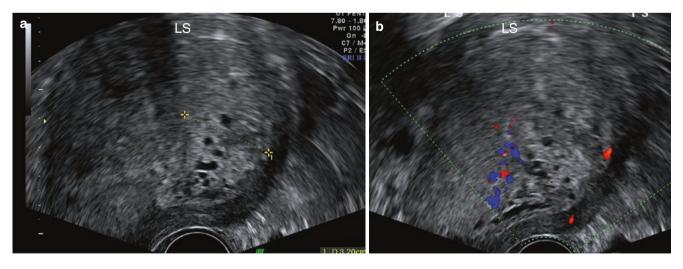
Molar pregnancy (complete mole) at 8 weeks and 3 days. (a) The endometrium appeared thick (3.2 cm) and heterogeneous and showed tiny cystic spaces within, leading to the suspicion of a molar pregnancy. (b) No significant flow is seen on colour Doppler within this tissue, which may be because of the uterine position and low velocity of flows. Beta hCG in this patient was 1,51,236 mIU/mL
